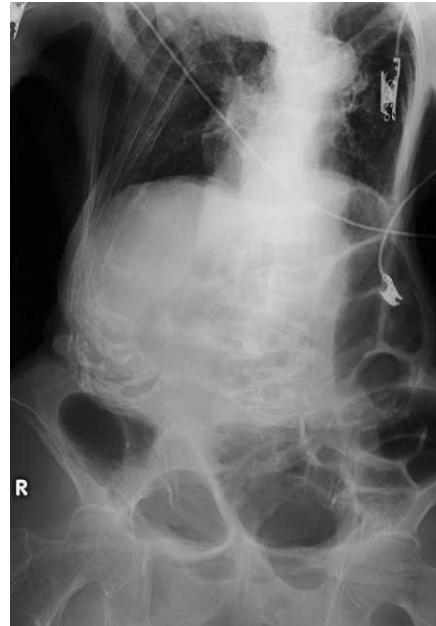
A plain abdominal X-ray.
